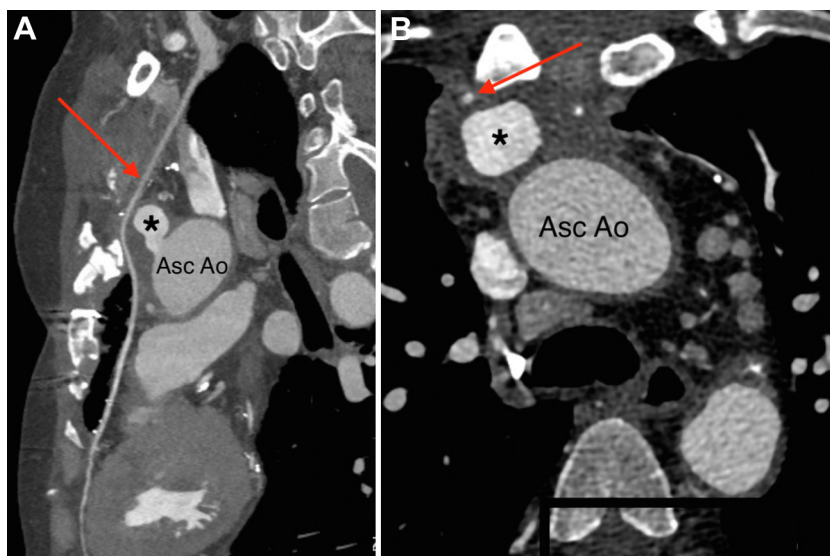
Chest CT with (A) curved planar reformat reconstruction of the RIMA graft and (B) transverse view showing the close proximity of the graft (arrow) to the pseudoaneurysm (asterisk) and the sternum. Asc Ao, Ascending aorta; RIMA, right internal mammary artery graft.
